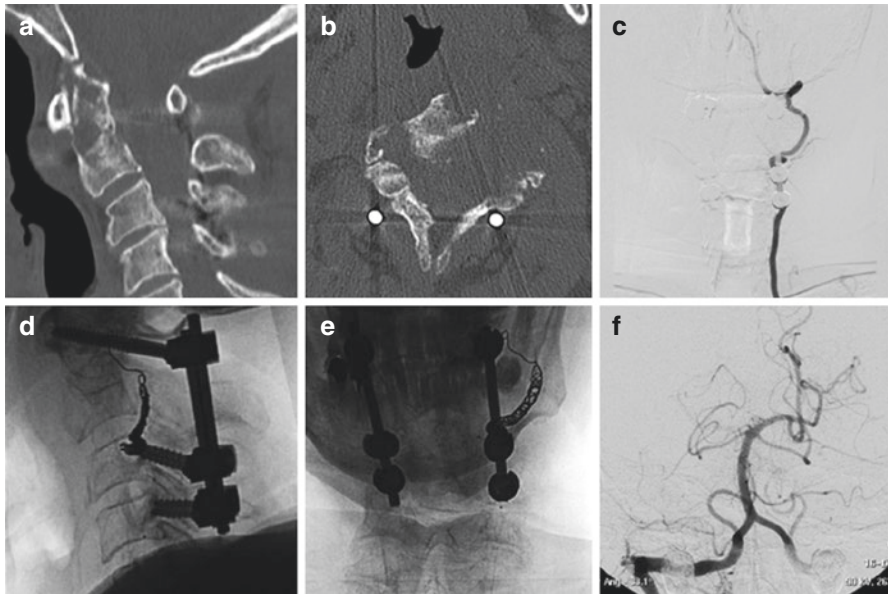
Preoperative therapeutic vertebral artery occlusion in a 62-year-old man with the recurrence of a previously operated chordoma of C2 on the left side. Non-enhanced CT images (a, b) demonstrate the chordoma of C2 vertebral body extending to the odontoid process. Patient undergoes a preliminary DSA (c), after which occlusion of the left vertebral is realized with platinum coils (d, e). Right vertebral selective angiogram (f) shows a perfect flow in the basilar artery and a reverse flow feeding the distal left vertebral
